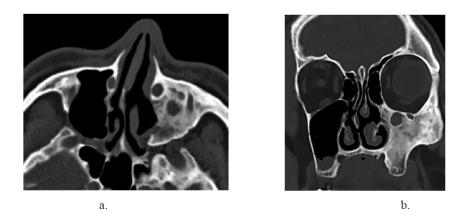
(case 2). 58-year-old male patient with fibrous dysplasia. (a) Axial and (b) coronal paranasal sinus computed tomography showing an osseous lesion that completely obliterates the maxillary sinus on the left and includes areas of soft tissue density in the ground glass areas, including the left upper maxillary alveolar process in the inferior part.
